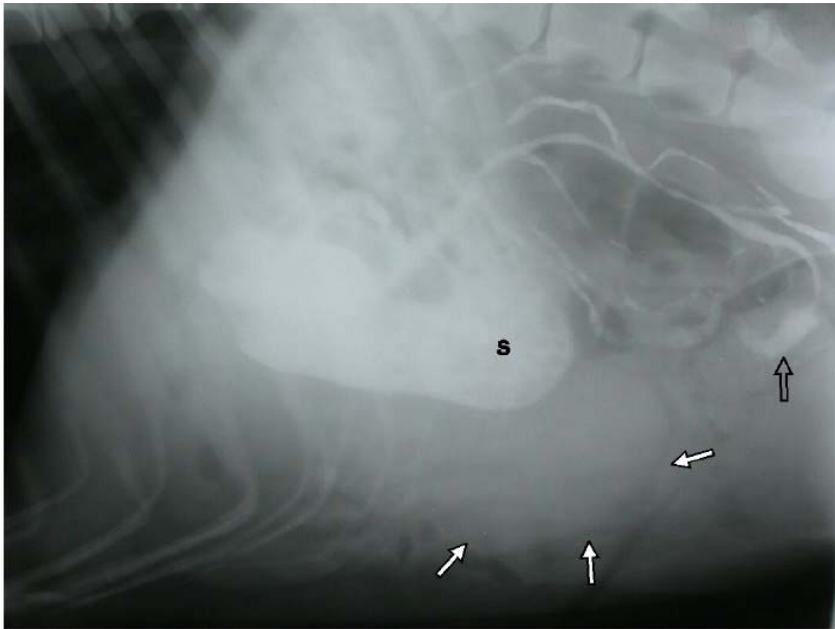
Lateral radiography of the abdominal cavity showing the presence of non-typical radiopaque finding just below the stomach (white full arrows). The stomach filled with contrast media (S) is extended beyond its normal location but is not enlarged. Small intestines having small amount of contrast media are raised near to the spine (empty arrow).
